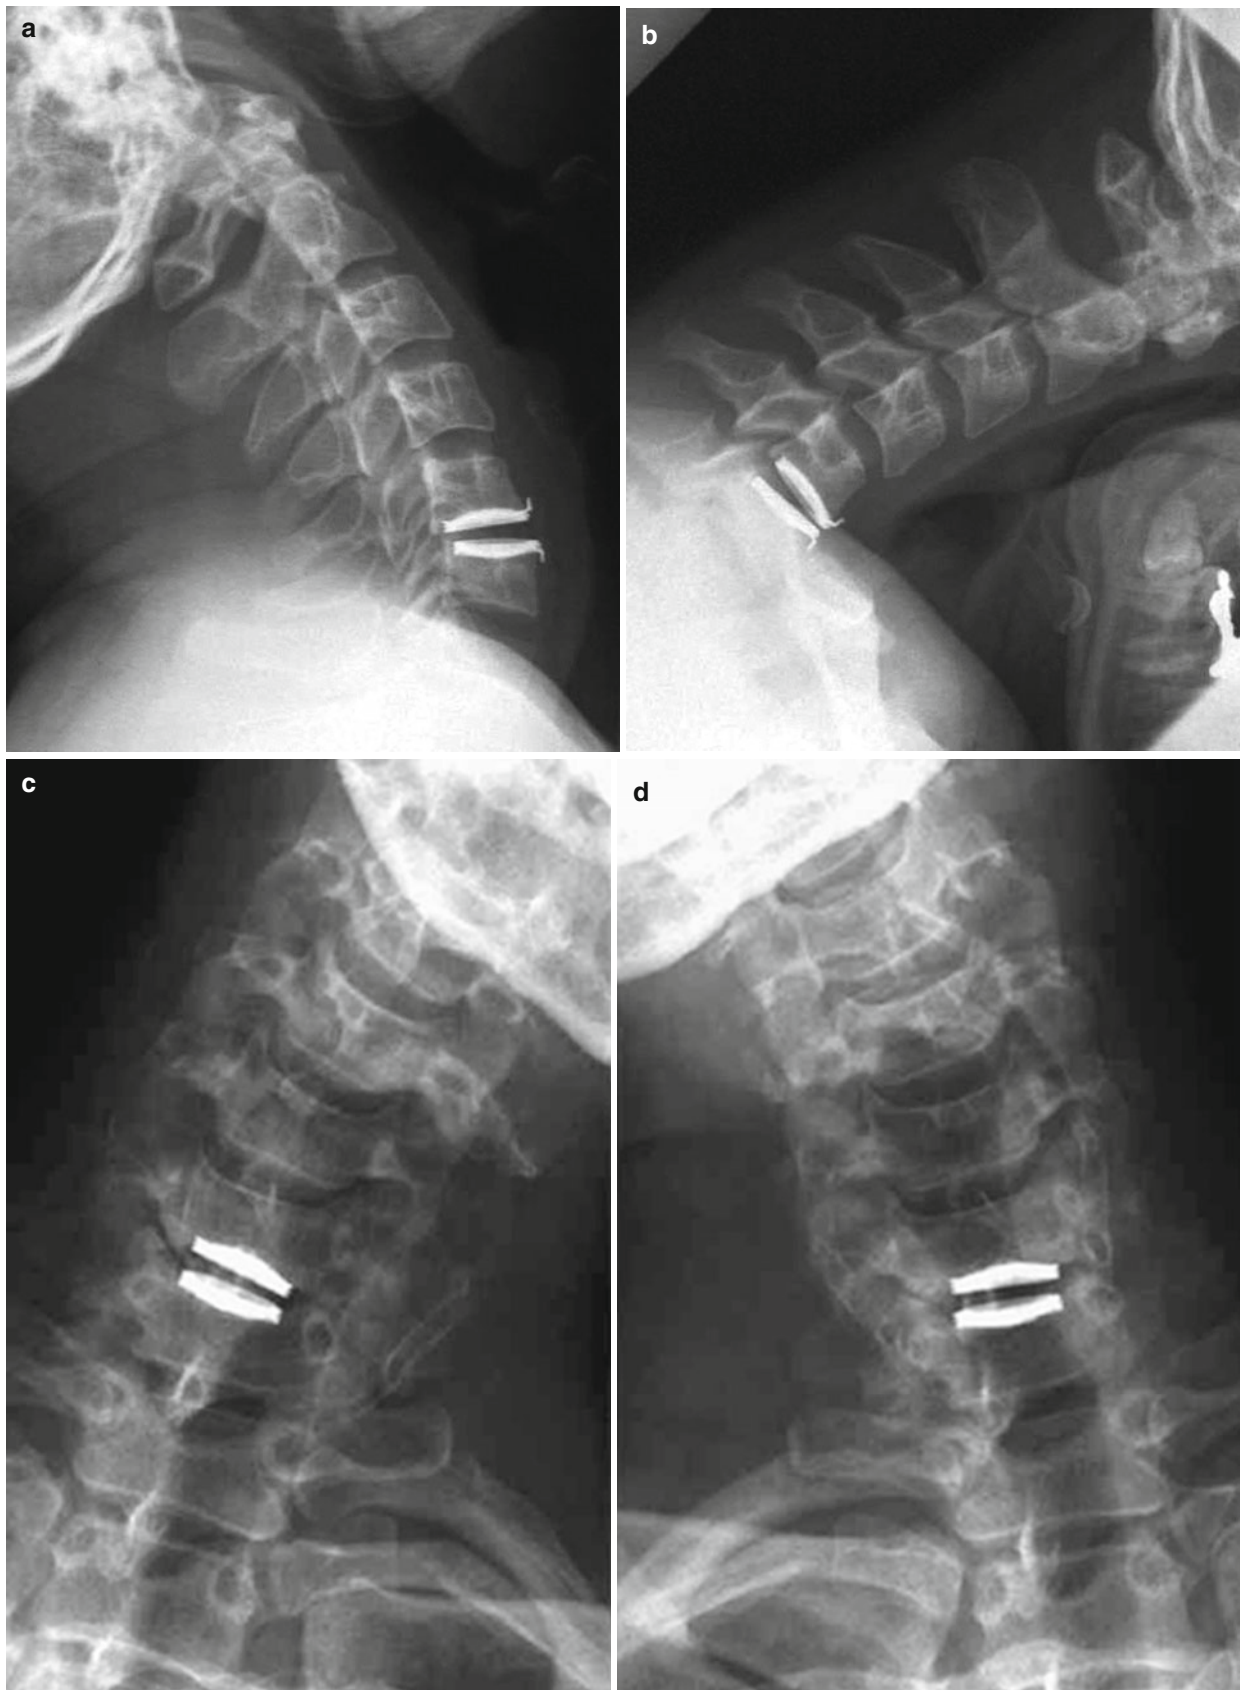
(a–d) Radiographs of patient with single-level Bryan cervical disc arthroplasty device (Images provided by Medtronic Sofamor Danek USA, Inc.)
